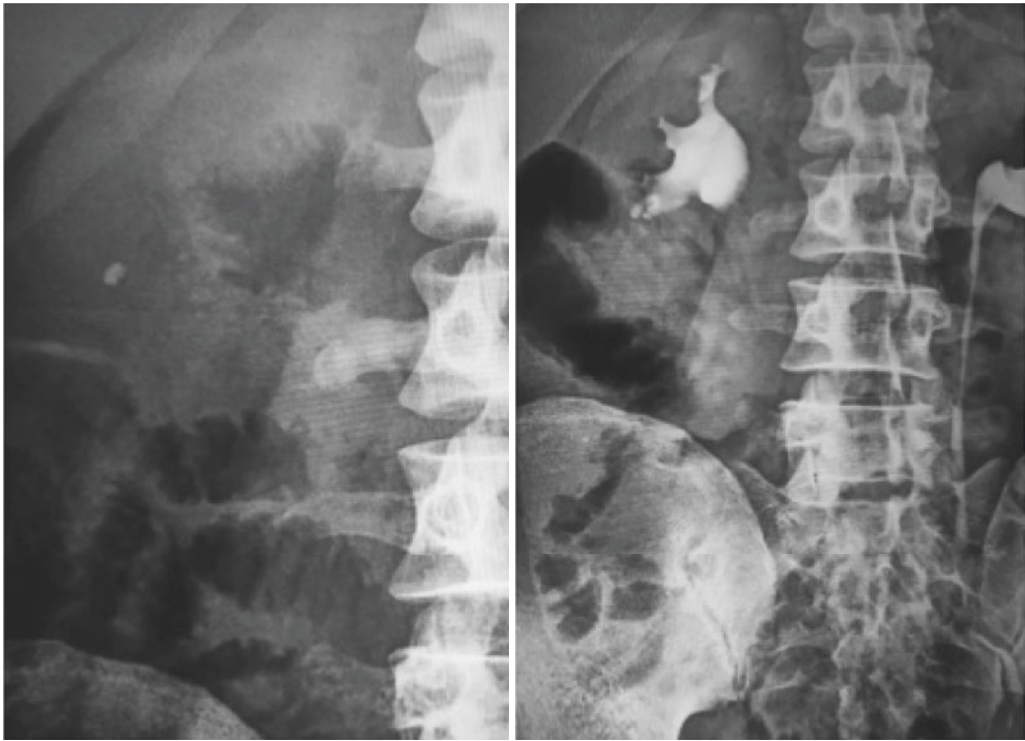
Presence of stone in anterior or posterior calyx cannot be identified in X-ray KUB and IVU films
